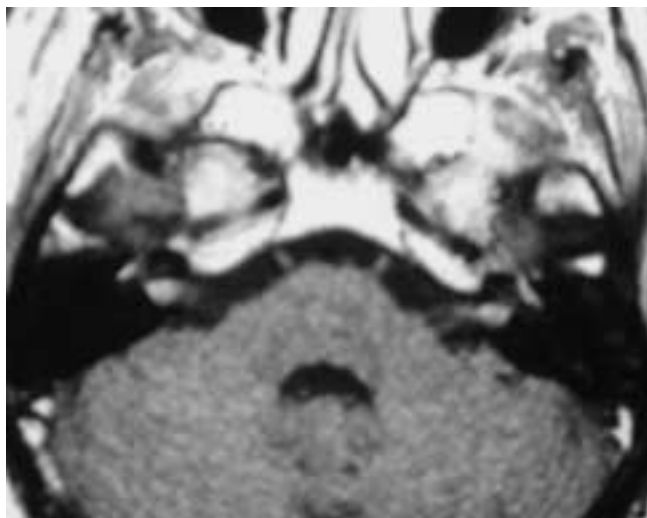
Dejerine-Sottas disease. T1-weighted postgadolinium image. This is a rare case of intracranial nerve involvement in Dejerine-Sottas disease demonstrating bilateral intracanalicular acoustic nerve hypertrophies, which show intense enhancement. This pattern may not be distinguishable from that of bilateral vestibular schwannomas seen in NF2. The same patient also has bilateral trigeminal nerve hypertrophies in Meckel's cave, with marked enhancement (not shown).
